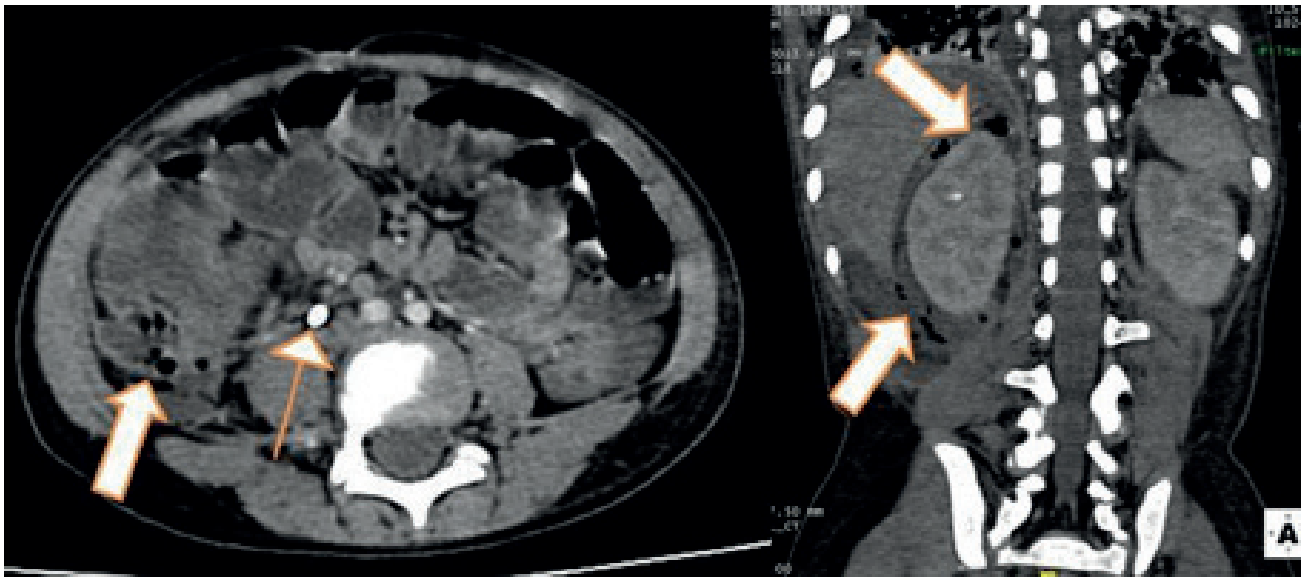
Axial and coronal contrast-enhanced CT images showed retroperitoneal air and inflammation (thick white arrows). In addition, the axial CT image showed appendicolith (thin white arrow).
